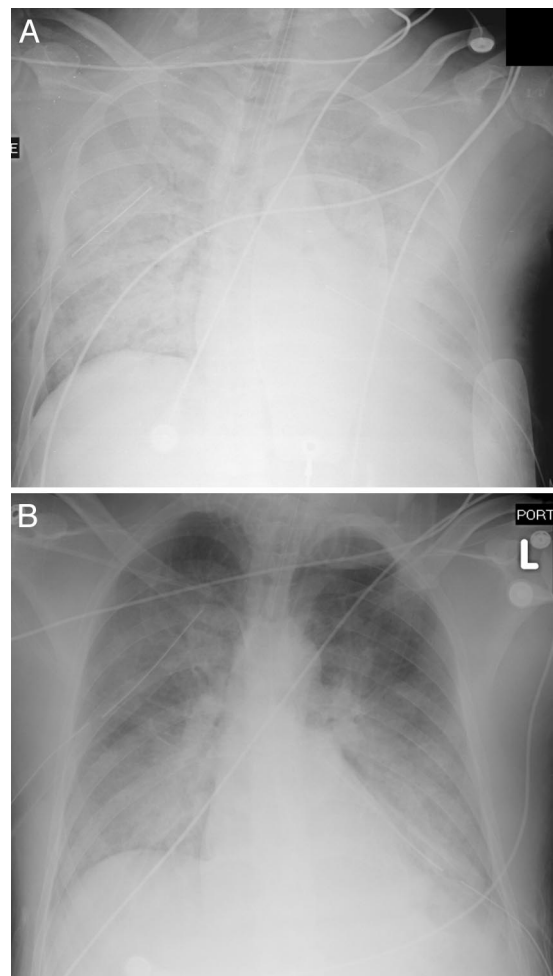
Chest radiographs (A) at admission and (B) on the day after admission.
